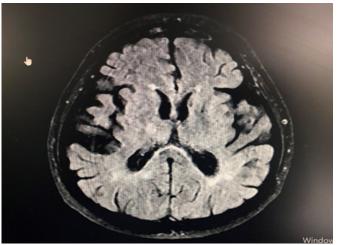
Follow-up FLAIR image obtained one month later shows significant regression of the lesions.
